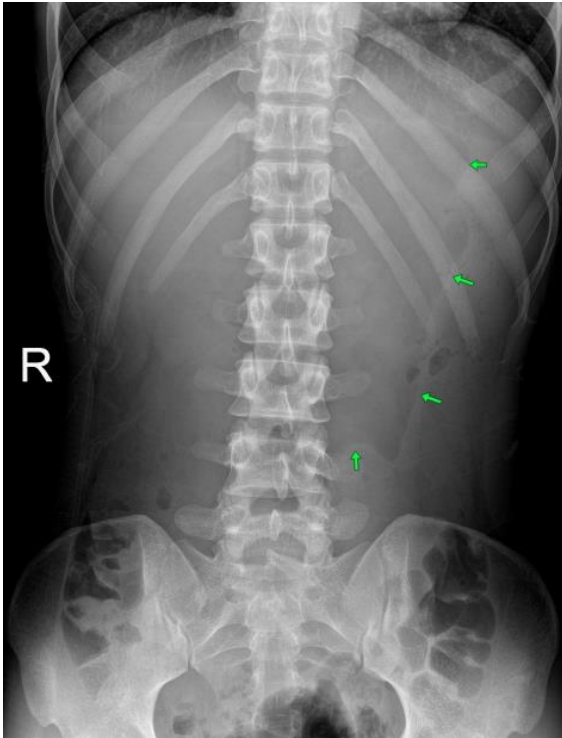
Supine abdominal radiograph showing gross dilatation of the gastric cavity (green arrows) extending to the central abdomen. No evidence of small and large bowel dilatation. No features of pneumoperitoneum.
